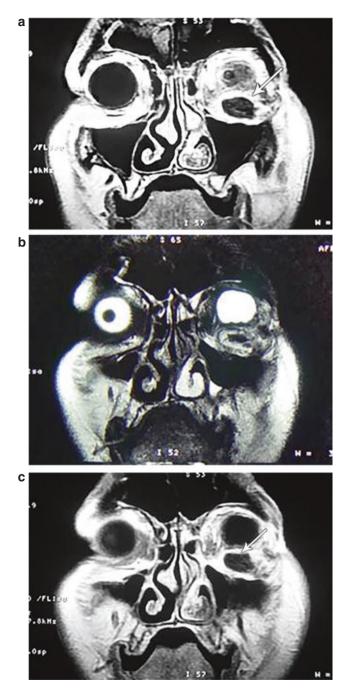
a In MRI, the mass seems to be hypo-intense in T1W image. b The lesion is hypo-intense in T2W image. c After contrast injection, the mass in the inferior rectus muscle is not enhanced
